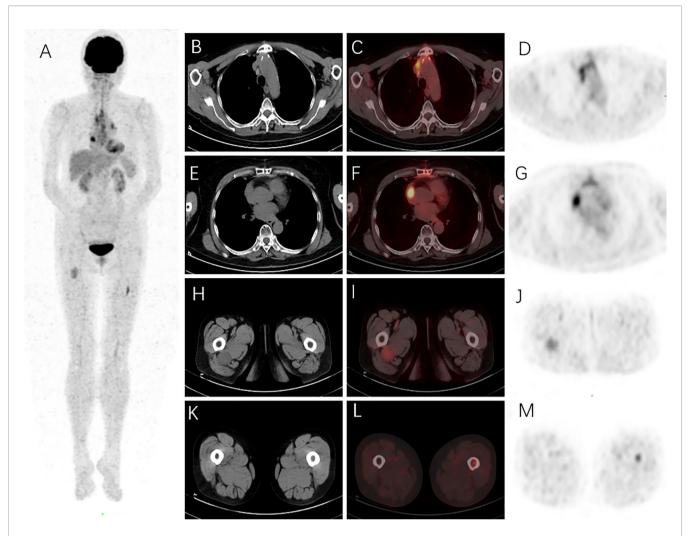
¹⁸F-FDG PET/CT was performed on this patient to evaluate the extent of the Langerhans cell histiocytosis (LCH). The maximum intensity projection (MIP) revealed increased ¹⁸F-FDG uptake in the chest, left femur, and right thigh regions (A). Surgery-related changes of the sternum on the mediastinal window of axial CT (B) were shown with diffusely high ¹⁸F-FDG uptake and SUVmax as 4.08 on axial PET/CT fusion (C) and PET images (D). An ¹⁸F-FDG-avid lesion in the right atrial appendage was found with SUVmax as 7.08 on axial PET/CT fusion (F) and PET images (G), and no specific abnormal density was found in the corresponding region on the mediastinal window of axial CT image (E). A round mass (about 3.7 × 3.1 cm) in the right upper thigh on the soft tissue window of axial CT (H) was revealed with SUVmax as 3.20 on axial PET/CT fusion (I) and PET images (J). A hypermetabolic lesion in the left upper femur was found with SUVmax as 3.98 on axial PET/CT fusion (L) and PET images (M); bone marrow density was slightly increased (K).
